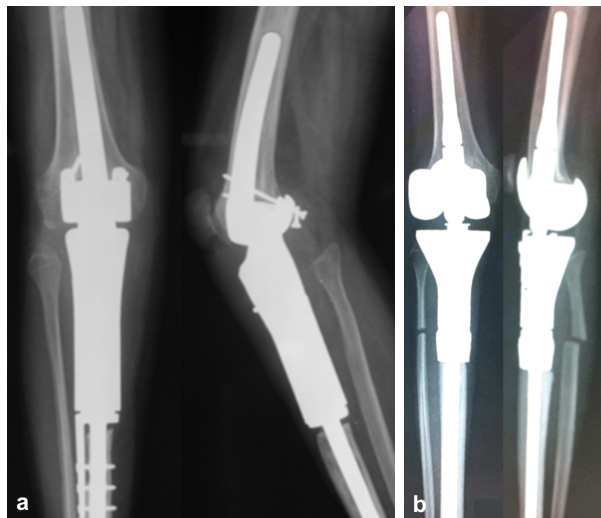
(a and b) Post-operative X-ray aspects: two different types of prosthesis, antero-posterior and lateral incidence; knee prosthesis after limb-sparing surgery.
